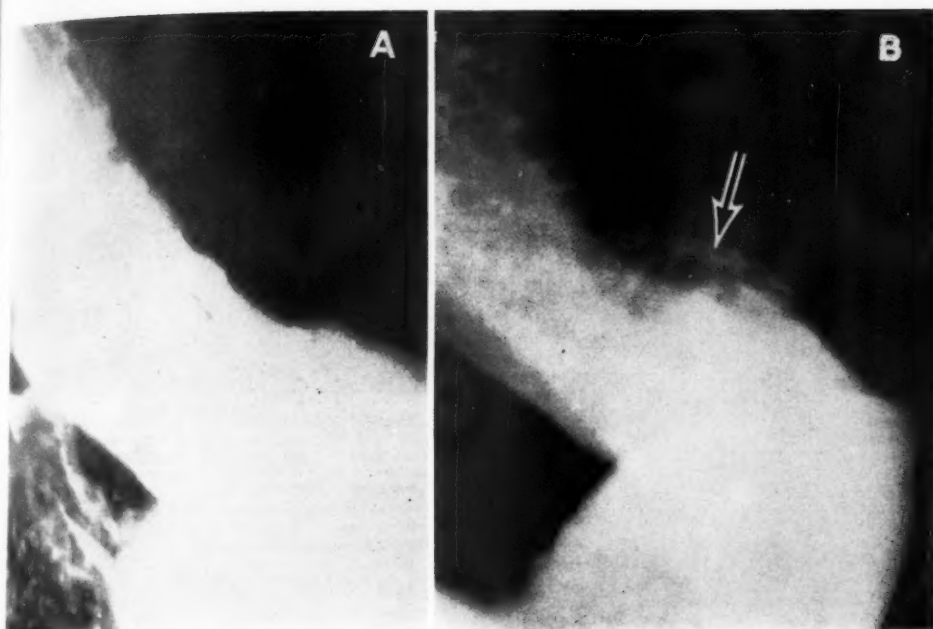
Benign superficial greater curvature ulcer undetected roentgenologically. A. Upper gastrointestinal roentgenogram, March 26, 1959, interpreted as negative save for situs inversus abdominis.
